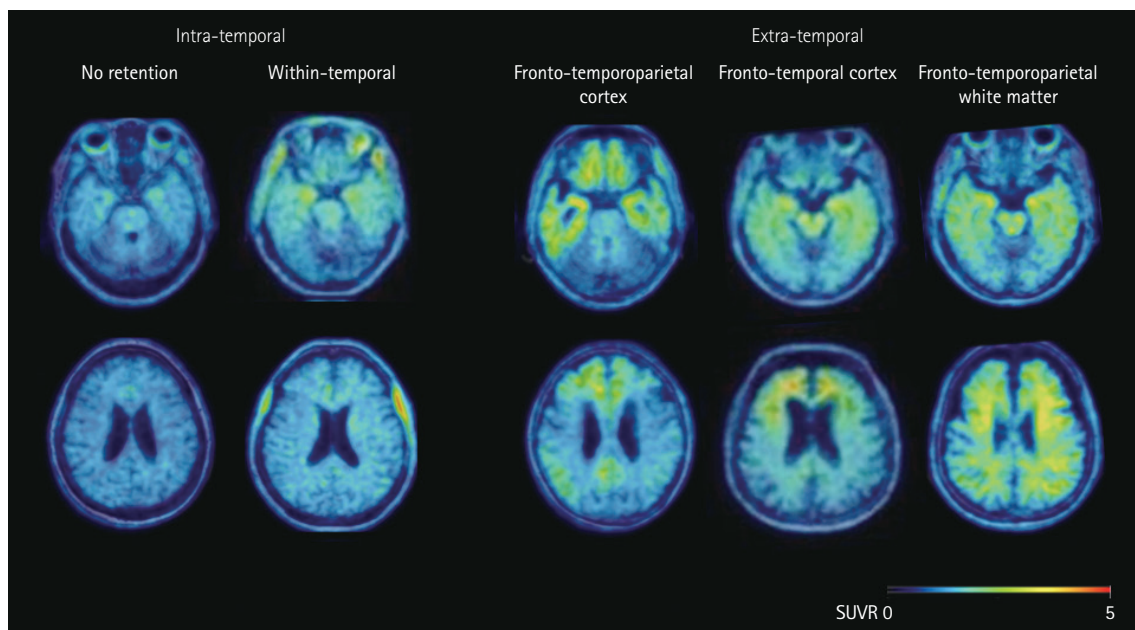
Representative images of the standardized uptake value ratio (SUVR) for [^{18}F]THK-5351 in positron-emission tomography in amyloid-negative Alzheimer's disease. Retention patterns were visually classified into intratemporal spread (no retention or retention only within the temporal cortex [WT]) and extratemporal spread (retention in the frontotemporoparietal cortex [FTP], retention in the frontotemporal cortex, or diffuse retention in the frontotemporoparietal white matter rather than in the gray matter [FTP-WM]).
